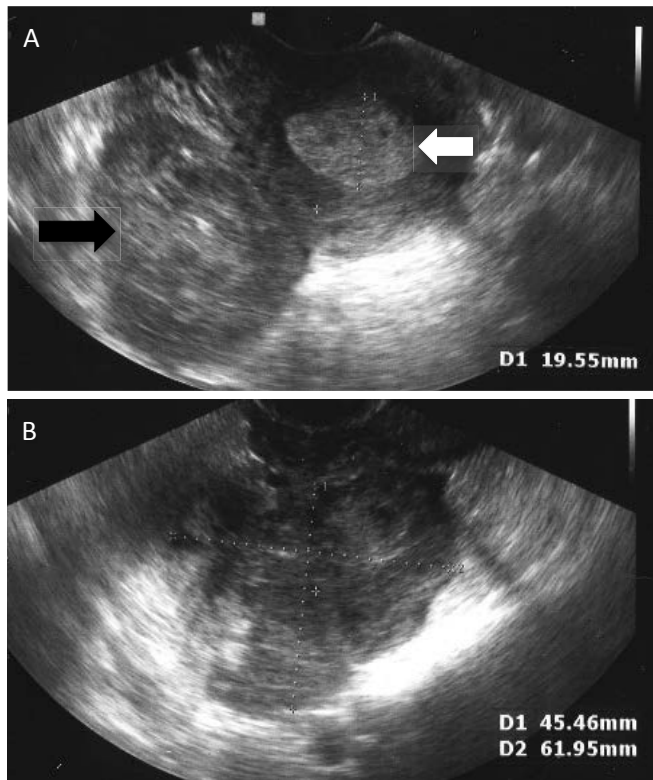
Ultrasound images of AGCT. A. A largely solid unilateral mass is present in the ovary (black arrow), and a thickened (19.6 mm) endometrium is seen in the uterus (white arrow). B. A mainly solid unilateral mass in the ovary measuring 62 x 46 mm.
